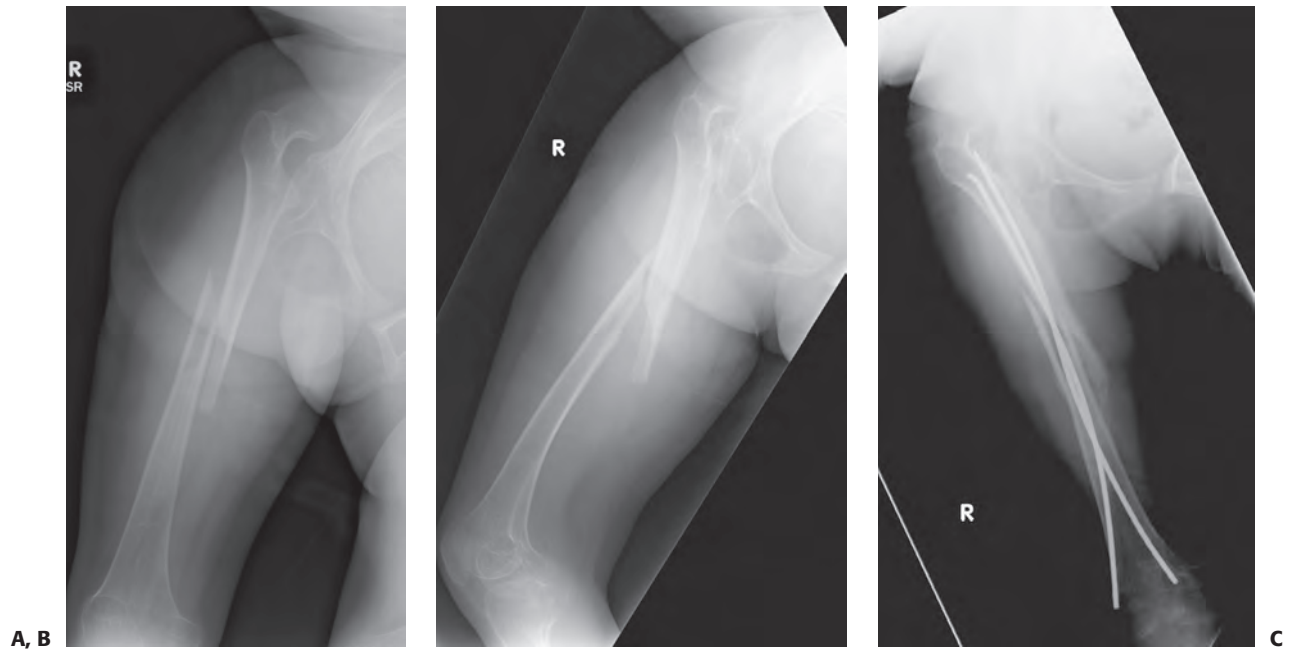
A 12-year-old girl with cerebral palsy and in-house-walking capabilities had an unwitnessed trauma to the right thigh, developing pain and deformity. Radiographs showed a displaced fracture of the femoral shaft (A, B). The patient underwent closed reduction followed by titanium elastic nail fixation. At 6 weeks follow-up, there was abundant callus formation (C, D). (Figures reproduced with permission from The Childrens Orthopaedic Center, Los Angeles, CA.)
